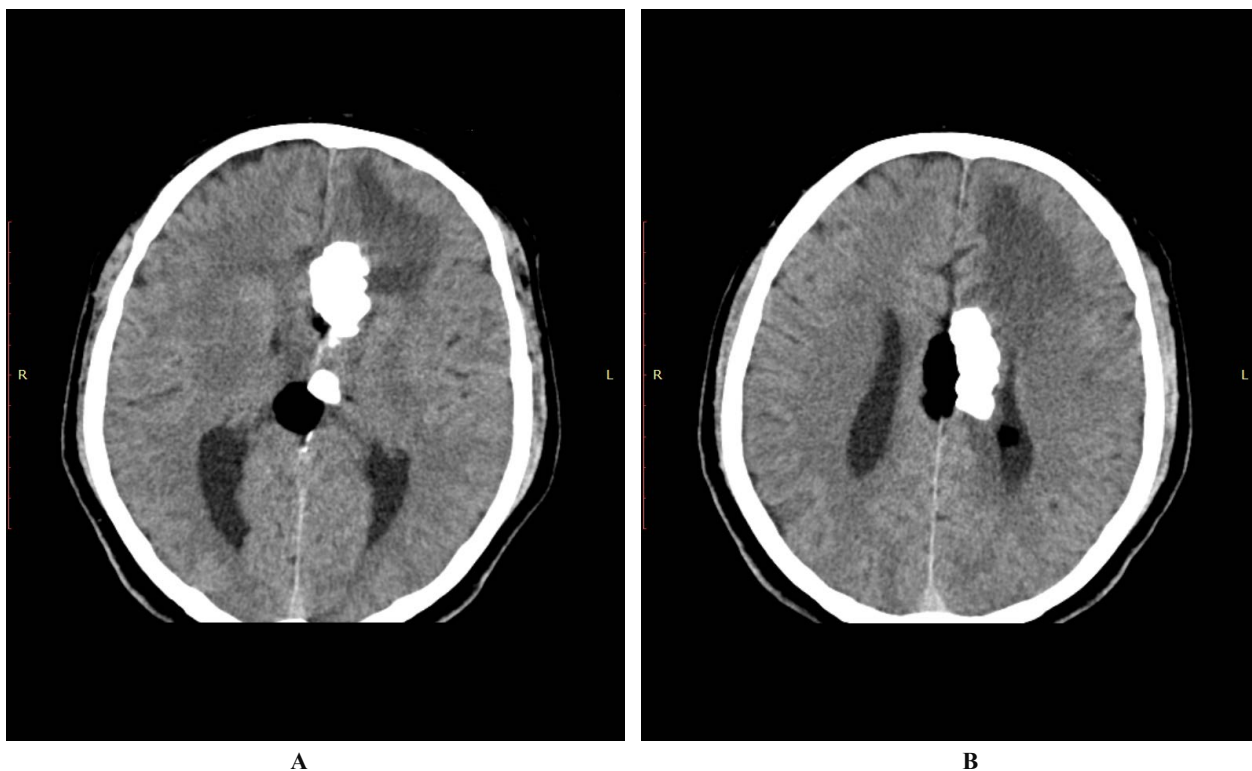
CT imaging presentation. A-B) Corpus callosum agenesis together with a tubulo-nodular lipoma
